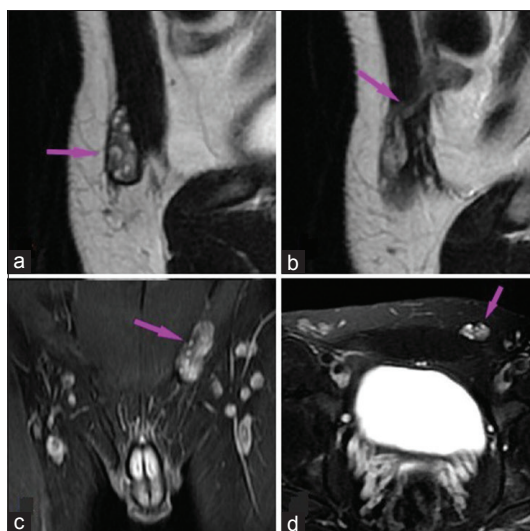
A 19-year-old individual with ovotesticular disorder of sex development who presented with progressive bilateral breast enlargement. (a) Parasagittal T2-weighted MRI section through the left inguinal region shows the left gonad containing a large number of high signal foci, consistent with cystic areas (arrow). (b) Parasagittal T2-weighted MRI section through the left inguinal region demonstrates the vas deferens adjacent to the left gonad (arrow). (c) Coronal short tau inversion recovery MR image shows the left gonad located in the left inguinal region (arrow). (d) Axial fat-suppressed T2-weighted MR image depicts the undescended left gonad (arrow).
